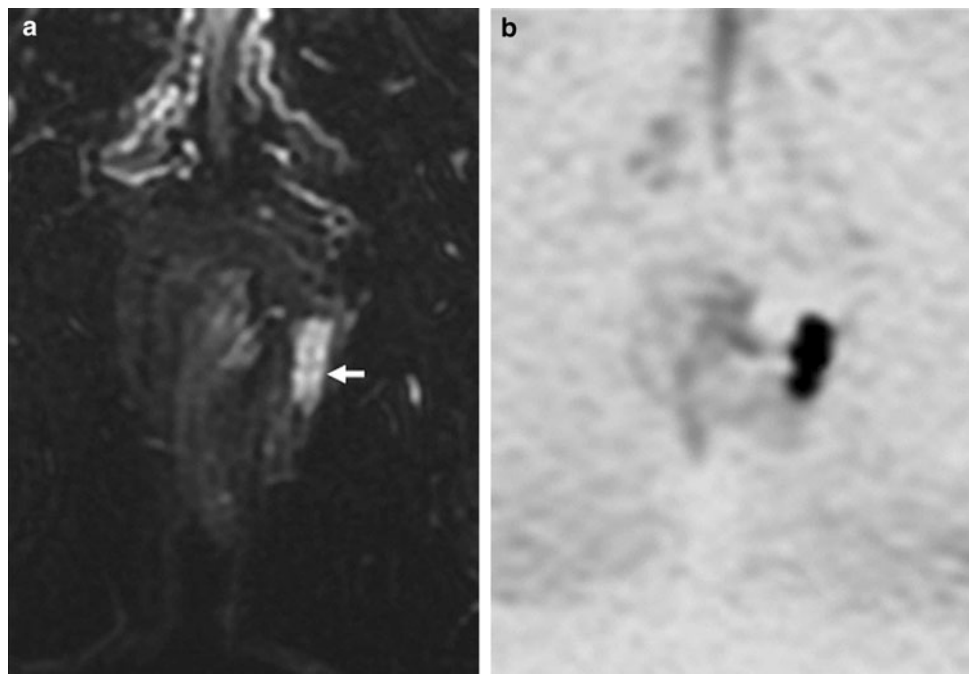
A 44-year-old woman presented with a left supralevator abscess due to ulcerative colitis. a Fat-suppressed T2WI shows a right supralevator abscess as a high signal intensity lesion (*arrow*). b DWI shows the high signal intensity abscess, but cannot provide information about the anatomical position. On the other hand, fat-suppressed T2WI can be used to understand the location of the abscess and its relation to the levator ani. Assessing the relation to this muscle is an important task when determining the treatment
